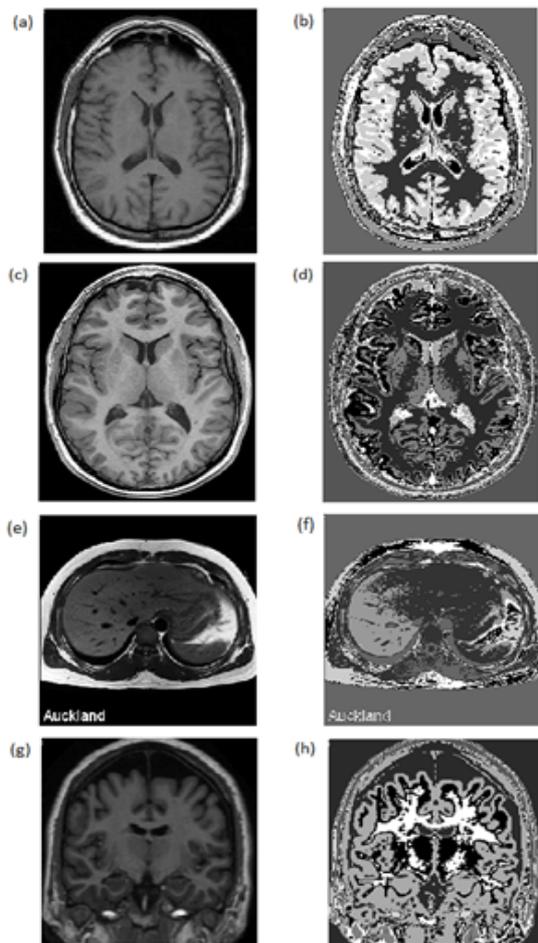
(a,c,e,g) Original MRI images, (b,d,f,h) Clustered MRI images.
